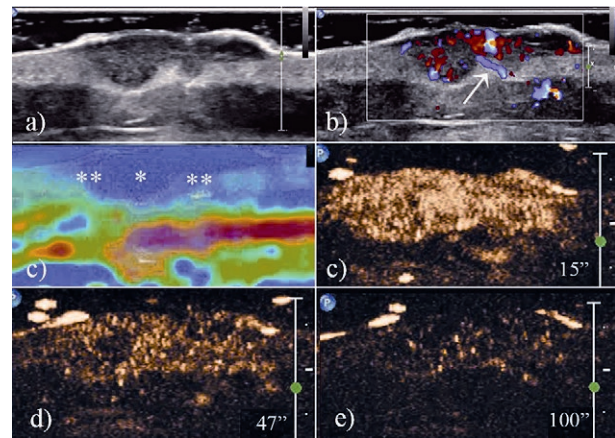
Ultrasonographic aspect; a) gray scale US: discrete exophytic and polycyclic tumoral lesion with imprecise delimitation and inhomogeneous content; b) color Doppler: intense vascular signal of the tumor; vessels have a regular spatial distribution, in an arborescent manner. c) real-time elastography using a color map (blue – rough area, red – low rigidity): the structure is more firm than the surrounding tissues; the tumoral rigidity is increased in the center of the lesion (*) compared to the periphery (); d) i.v contrast examination: arterial time of the upload; the upload is precocious (15 sec), intense and uniform (complete upload of vascular bed); the delimitation of the vascular bed corresponds to the delimitation of the tumor, as it results from the 2D examination and elastography; e) i.v contrast examination: partial download of the contrast agent from the area of interest (47 sec); the persistence of the vascularized aspect in the tumoral periphery may be noticed; f) i.v contrast examination: complete download of the contrast agent from the area of interest (100 sec); vascular bed is sketched by the presence of few vascular elements
